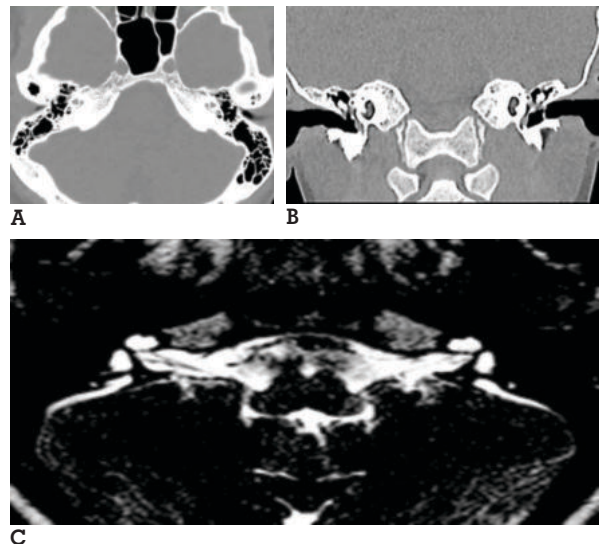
Bilateral incomplete partition type-II. A-Axial & B-coronal) HRCT section through cochlea shows absent modiolus in middle and apical turn to form cystic apex. C) Axial FIESTA image shows cystic apical part of cochlea with absence of inter-scalar septum and associated with B/L dilated Endolymphatic duct system.
